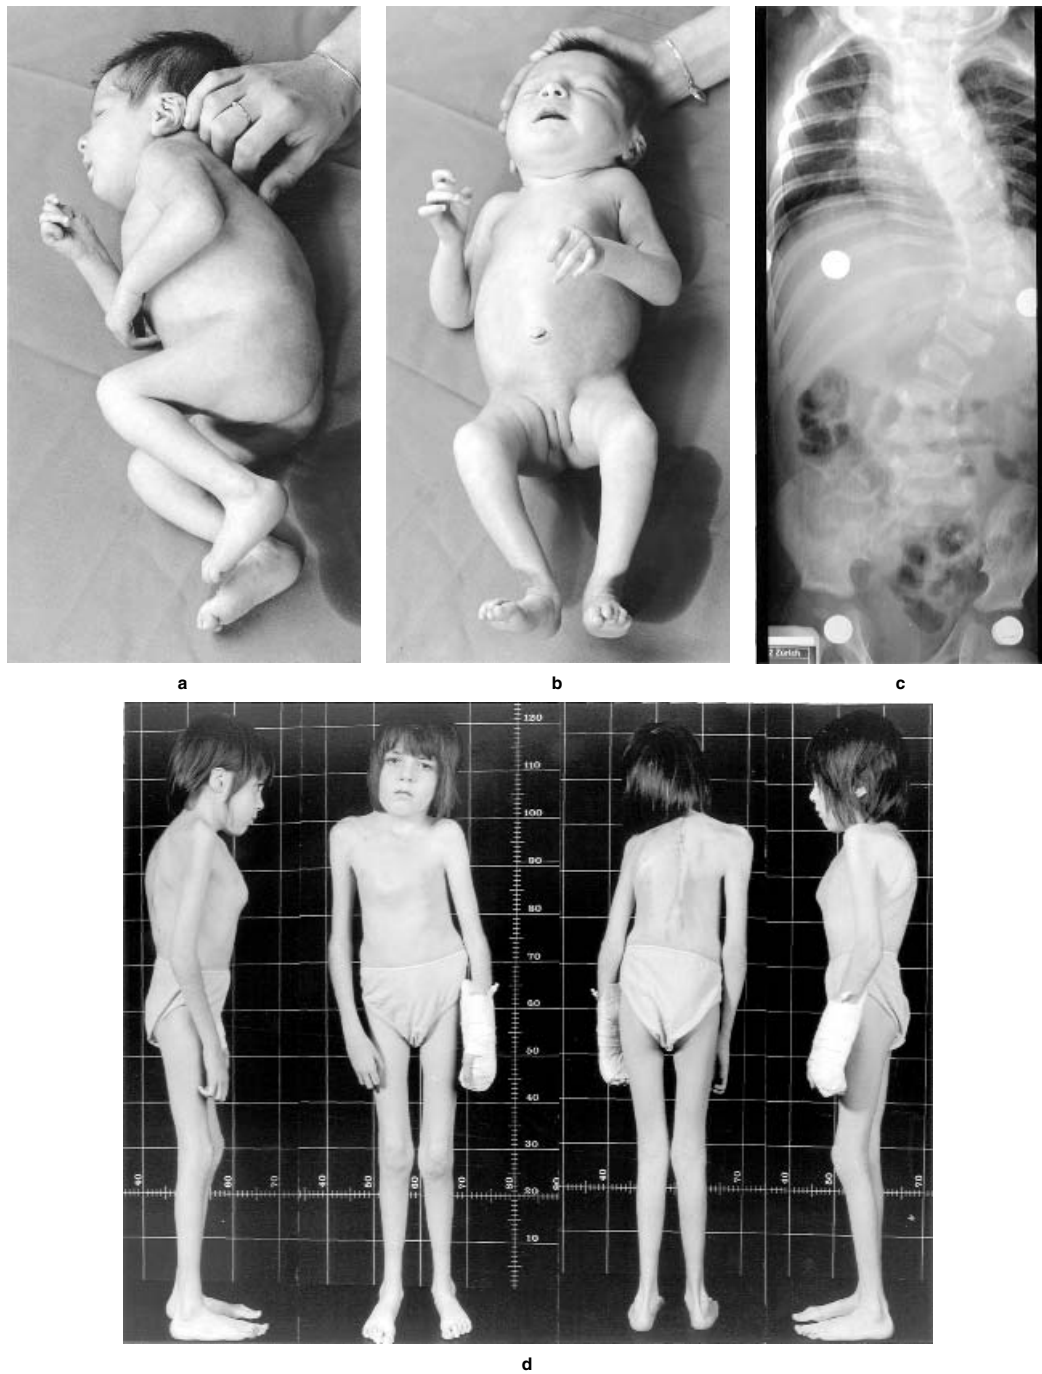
Congenital contractural arachnodactyly. R.R. is the third child of healthy, unrelated parents, born after a normal pregnancy and delivery. Her weight was 3070 g (25th centile), length 55 cm (>95th centile), and head circumference 34 cm (50th centile). Crumpled ears, joint contractures, arachnodactyly, and scoliosis were noted at birth. Numerous procedures had been performed to correct her severe scoliosis, beginning with bracing at 2 months, followed by halo traction and rod insertion at age 2.3 years. This was followed by repeated rod elongation, removal, and replacement. Although her initial growth curve was above the 97th centile, this flattened due to the severity of the scoliosis until it was only at the 3rd centile at age 5 years. Her pulmonary function was restricted. She had a normal 46,XX karyotype. Repeated echocardiographic examinations of her heart were normal, and the results of ophthalmologic examinations were normal. Her defect is due to a *de novo* missense mutation leading to skipping of exon 26. a and b: R.R. (at age 10 days) presents with contractures of the knees, hips, elbows, and fingers (arachnodactyly), dolichostenomelia, retrognathia, and crumpled ears. c: Radiograph at age 4 months shows severe and progressing scoliosis despite bracing. d: Severe kyphoscoliosis at age 6½ years despite numerous orthopedic interventions such as bracing at 2 months, halo traction with rodding at 2.3 years, removal of rod at 3.5 years, insertion of rod and partial spondylodesis at 3.7 years, removal of halo at 3.8 years, elongation of broken rod, repair and then removal of broken rod at 4 years, insertions of many rods at 6.3 years, and spondylodesis at 6.5 years. She has severe restrictive pulmonary dysfunction. (Courtesy of Dr. B. Steinmann.)
